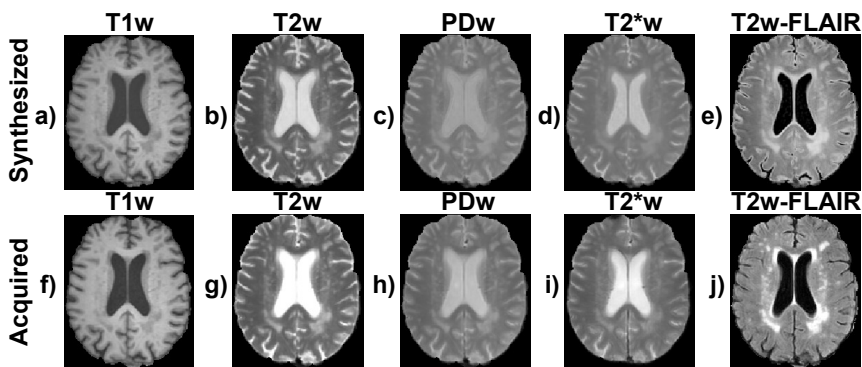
A representative axial slice of the weighted images synthesized from one set of the T1, T2, and PD maps computed by the CNN and their corresponding acquired images. a-e) The synthesized T1w, T2w, PDw, T2*w, and T2w-FLAIR images. f-j) Their corresponding weighted acquired images.
